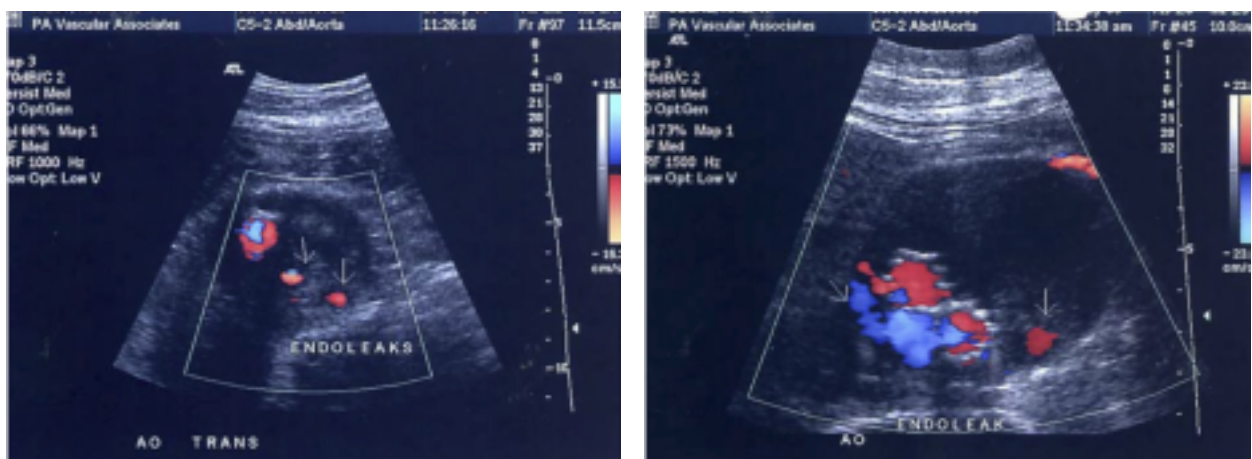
Duplex ultrasound examination demonstrating foci of Doppler signal outside of the stent but inside the aneurysm sac (arrows) in keeping with endoleaks. Adapted from (137).
